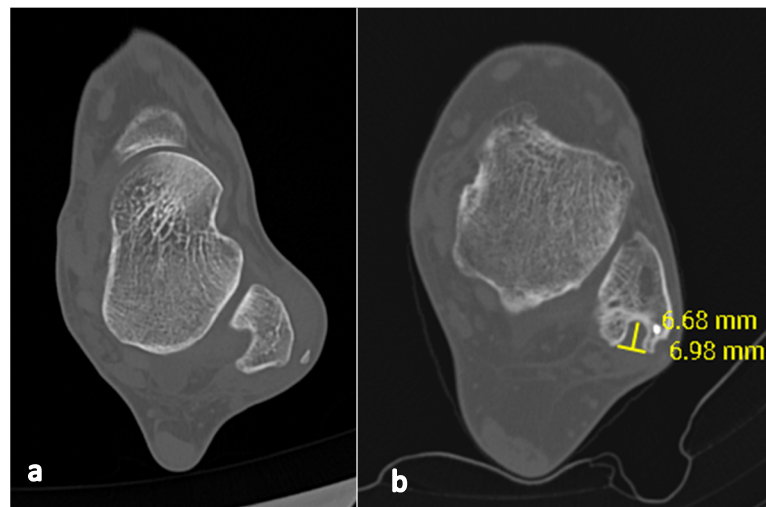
CT scan of a 44-year-old male. (a) Flat malleolus in the preoperative view; (b) CT scan after deepening of the retromalleolar groove.
